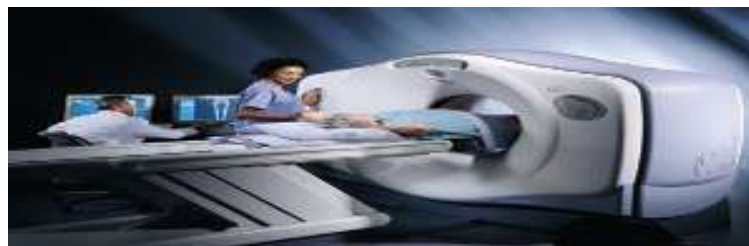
CT scan<sup>[15]</sup>
